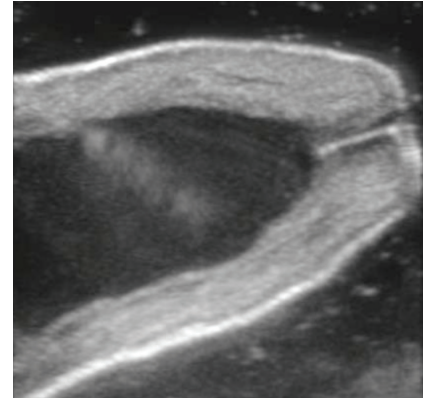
Normal teat ultrasonogram
